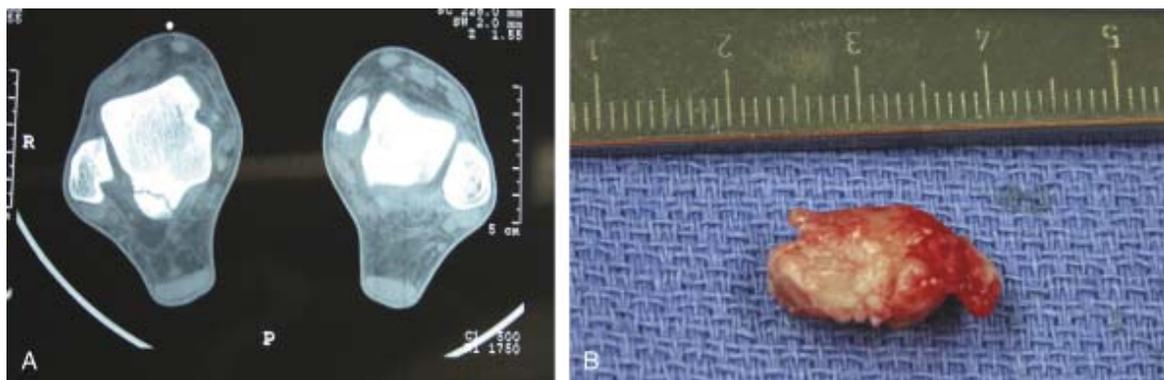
4 A, Computed tomographic scan demonstrating bony posterior impingement. B, Excised bony fragment. (Photographs by Christopher B. Hirose.)
